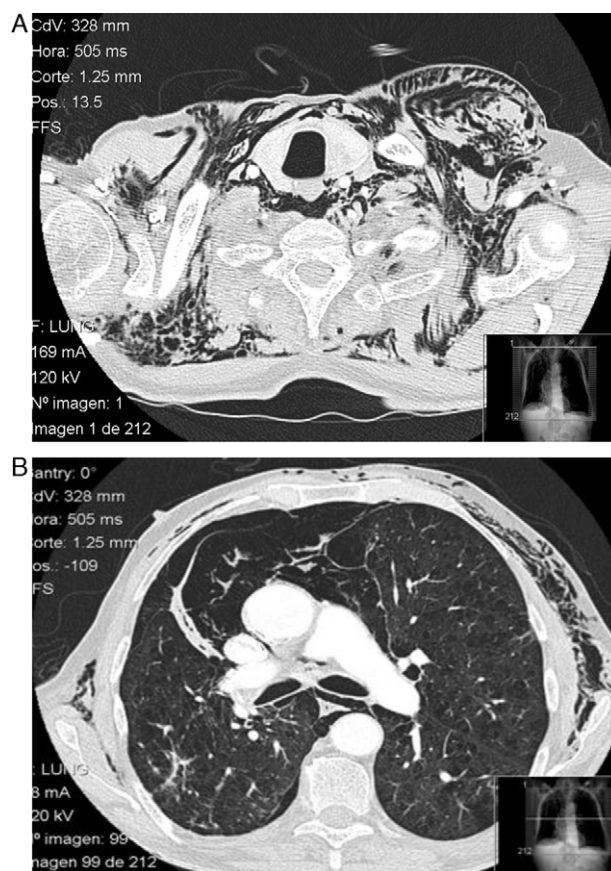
(A and B) Thoracic CT image showing the presence of gas in the subcutaneous and mediastinal tissue.
